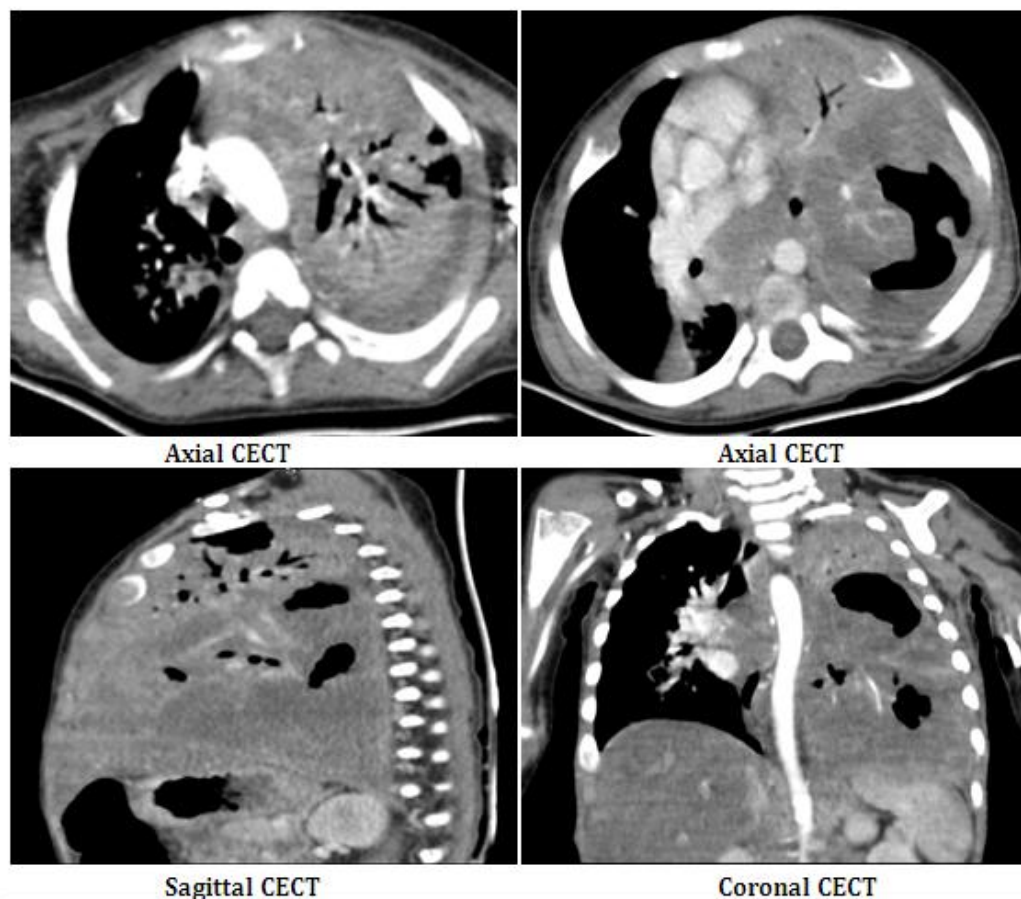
Contrast Enhanced CT Chest showed multiple hypo-enhancing areas involving the left upper lobe.
